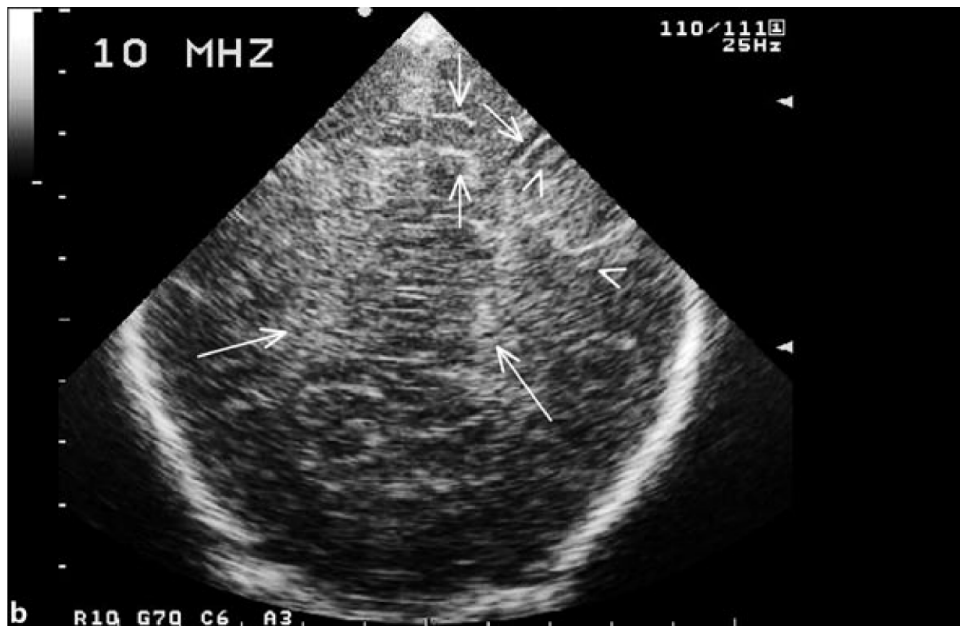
a Coronal ultrasound scan at the level of the parieto-occipital lobes in a full-term baby, born asphyxiated, using a transducer frequency of 7.5 MHz
